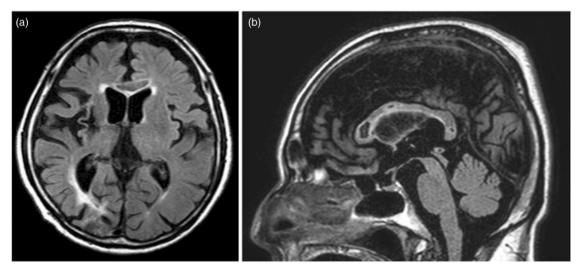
Representative images from the final follow-up (on 39th hospital day) (a, b) FLAIR imaging of axial and sagittal section. Further reduction of the hyperintensity and cavitation of the corpus callosum are noted.
